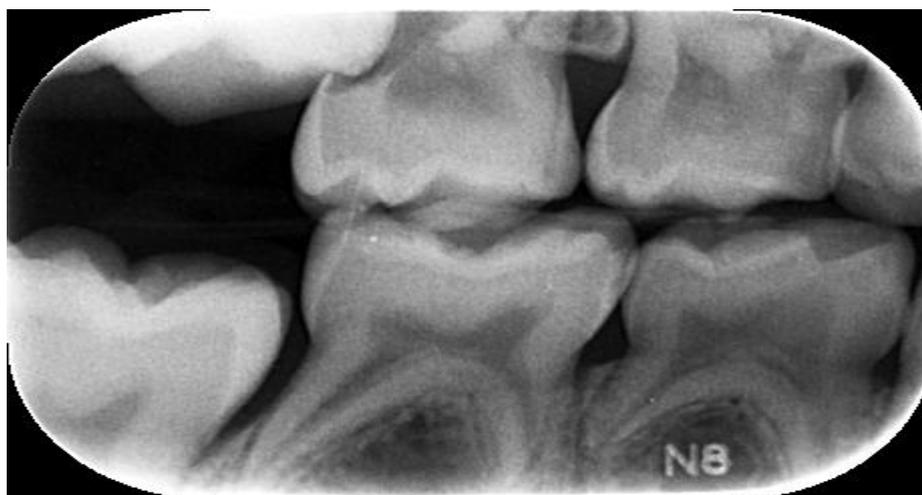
Pre-operative radiograph right side, indication of ectopic eruption of molars, decided to give 6 months to watch.
